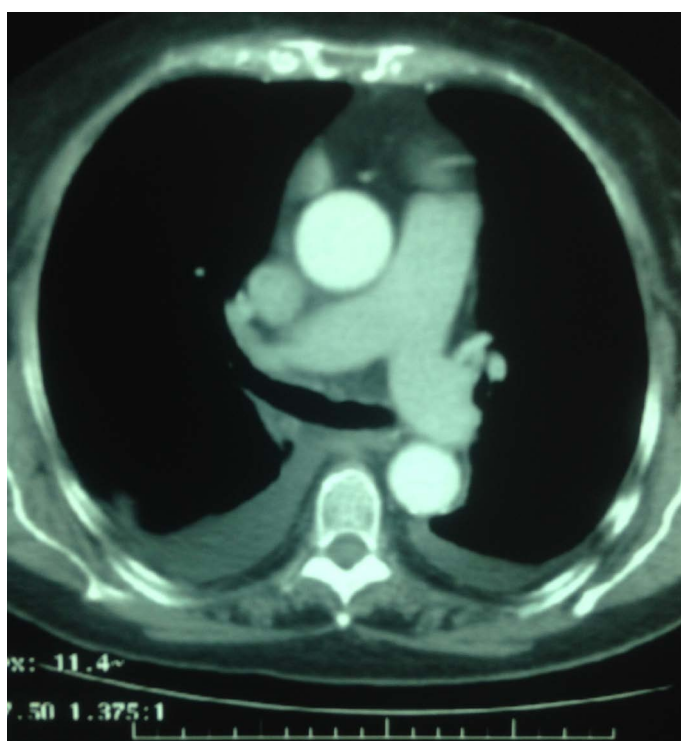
CT-scan with contrast enhancement showed a large heterogeneously enhancing solid lesion with irregular central necrosis measuring about 6.7 cm seen in the right side of mediastinum located posterior to the superior vena cava and the aortic arch. It was superior to the right pulmonary artery and lateral to the trachea. There is no evidence of hilar or mediastinal lymph node enlargement. There is collapse consolidation of the lower lung lobes seen with air bronchogram and right-sided pleural effusion. A small left-sided pleural effusion with atelectasis of the basal lung tissue is also noted. The rest of lung fields are clear.
